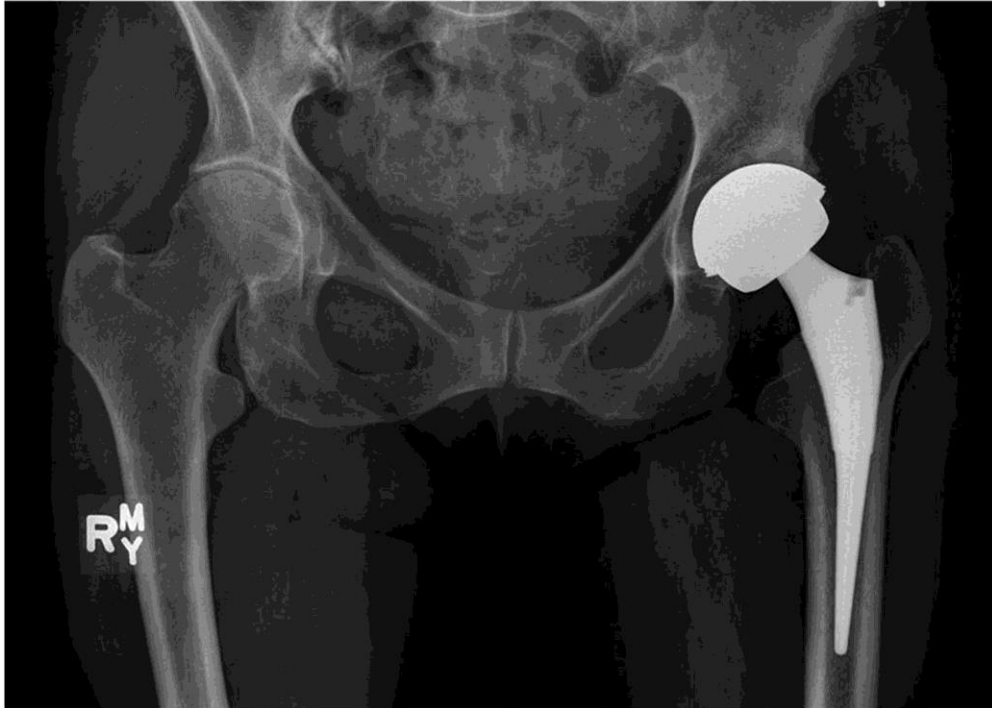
Anteroposterior pelvic radiograph for a patient who had metal-on-metal total hip arthroplasty (Williams, Greidanus, Masri, Duncan, & Garbuz, 2011)
